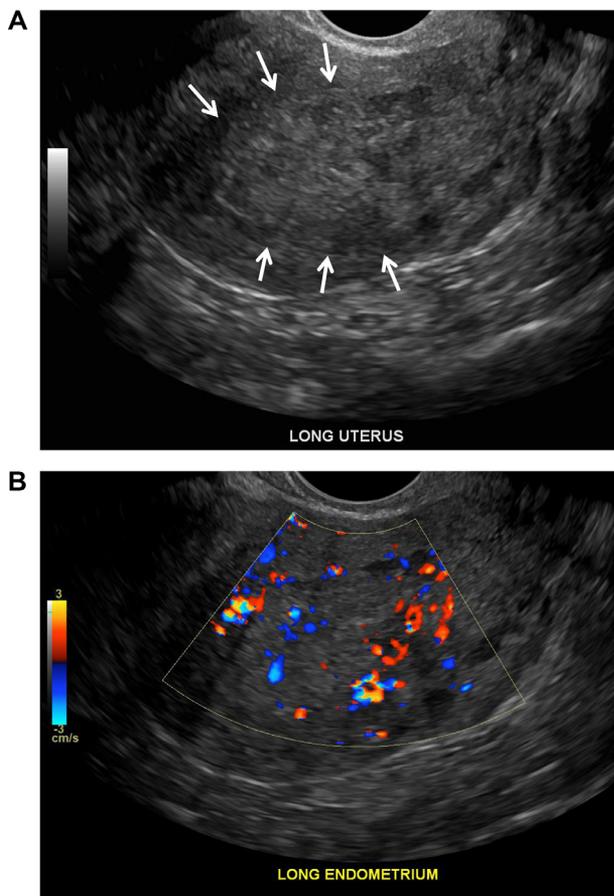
72-year-old female with postmenopausal bleeding. (A) Transvaginal sagittal ultrasound image of the uterus shows a markedly thickened and heterogeneous endometrium (arrows) measuring 24 mm with ill-defined anterior border (arrows) and no clear separation from the myometrium. Note some vascularity in the color Doppler US (B). At hysterectomy endometrial cancer with myometrial invasion was confirmed.
